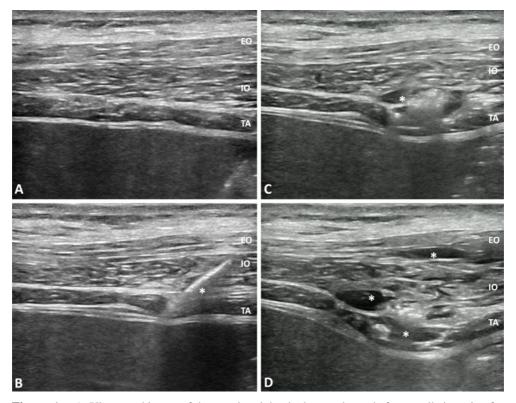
A. Ultrasound image of the anterior abdominal musculature before needle insertion for BTA injection. The layers of the EO, IO, and TA are marked respectively. B. Demonstration of the echogenic needle (*) being guided into the abdominal musculature. C. Saline hydrodissection (*) of the fascial planes of the IO and TA. D. Post-BTA injection displaying BTA fluid depot in the layers of the EO, IO, and TA (*).
